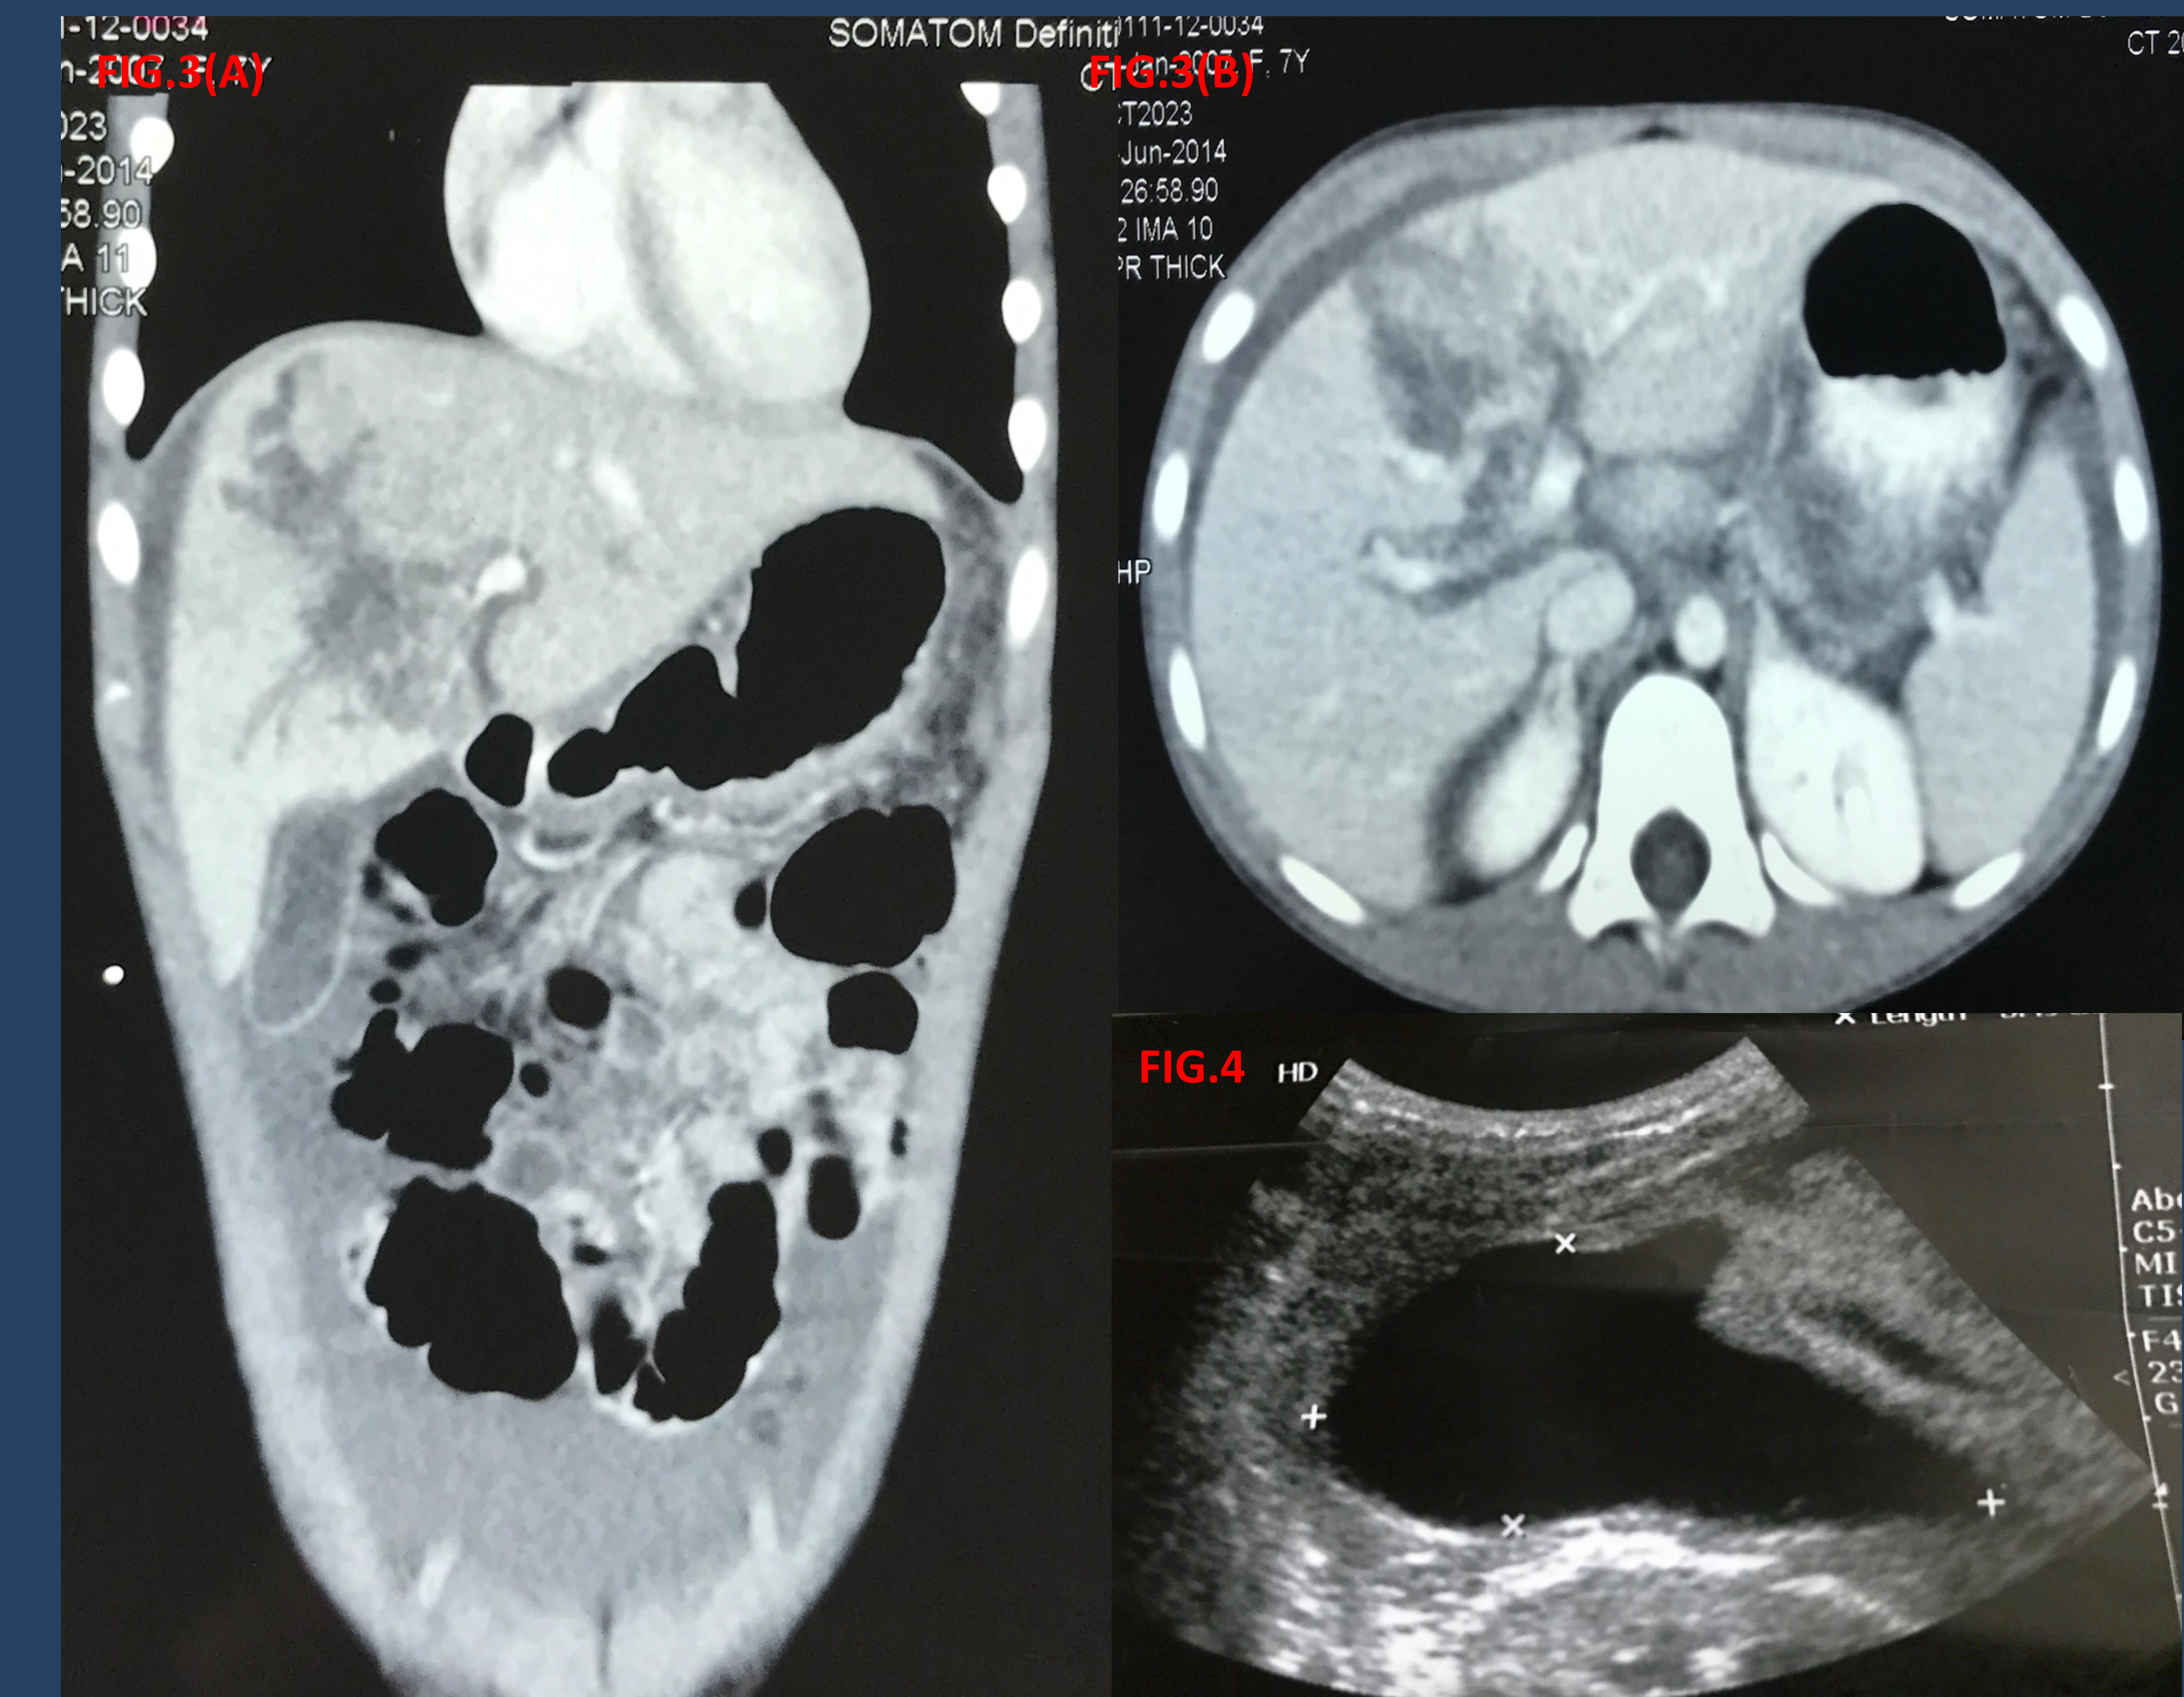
(a) and 3(b) : CT showed multiple lacerations involving segment VI with moderate haemoperitoneum.
